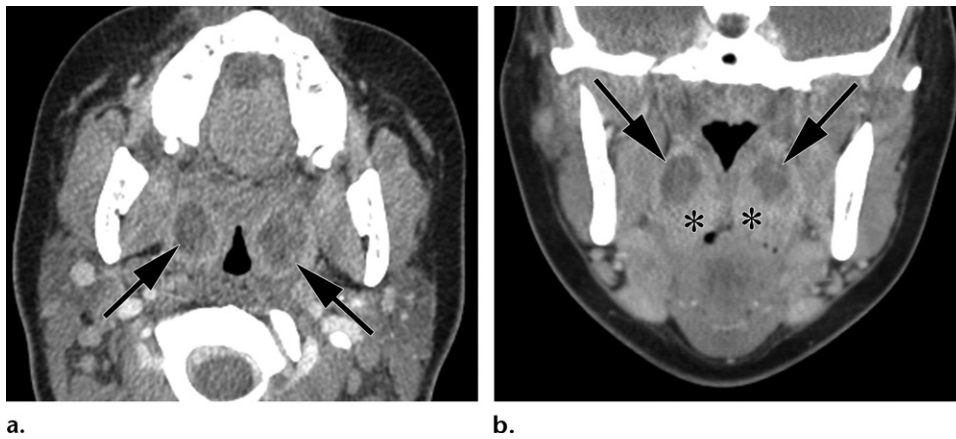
Bilateral PTAs in a 21-year-old woman. Axial (a) and coronal (b) contrast-enhanced CT images show bilateral low-attenuation collections (arrows) superolateral to the palatine tonsils (* in b).
